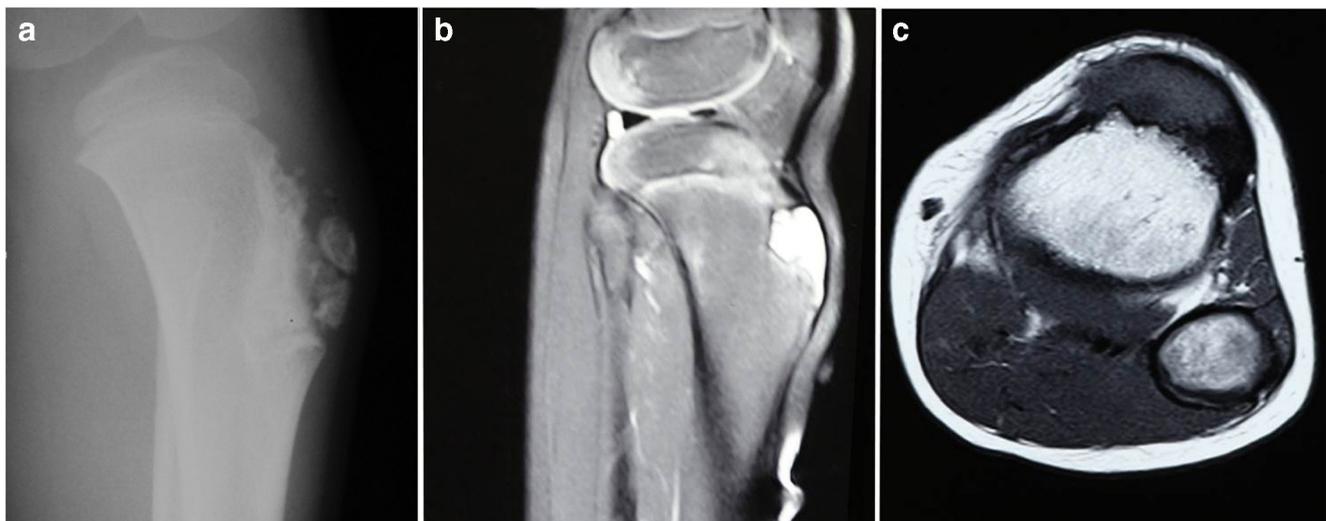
Periosteal chondroma mimicking Osgood-Schlatter’s disease. a Lateral radiograph showing the features of periosteal chondroma including cortical remodeling and intralesional calcification distal to the tibial tuberosity (case 3). b Sagittal T2-wighted MRI showing a
